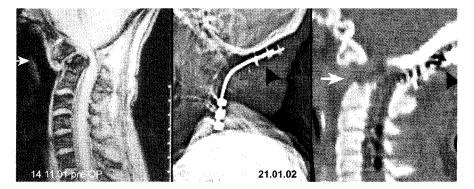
Sagittal MRI, TSE T2, TR 3500, TE 120 preoperative (14. 11. 01) (left). Complex congenital abnormality of the craniovertebral junction (white arrow) with displacement and local (vascular?) compression of the lower brain stem and upper cervical cord due to bony narrowing of the surrounding space as cause of acute posttraumatic tetraparesis. Sagittal spiral CCT control postoperatively (right) shows the resection of the bone after ventral approach and the dorsal cranio-cervical fixation
